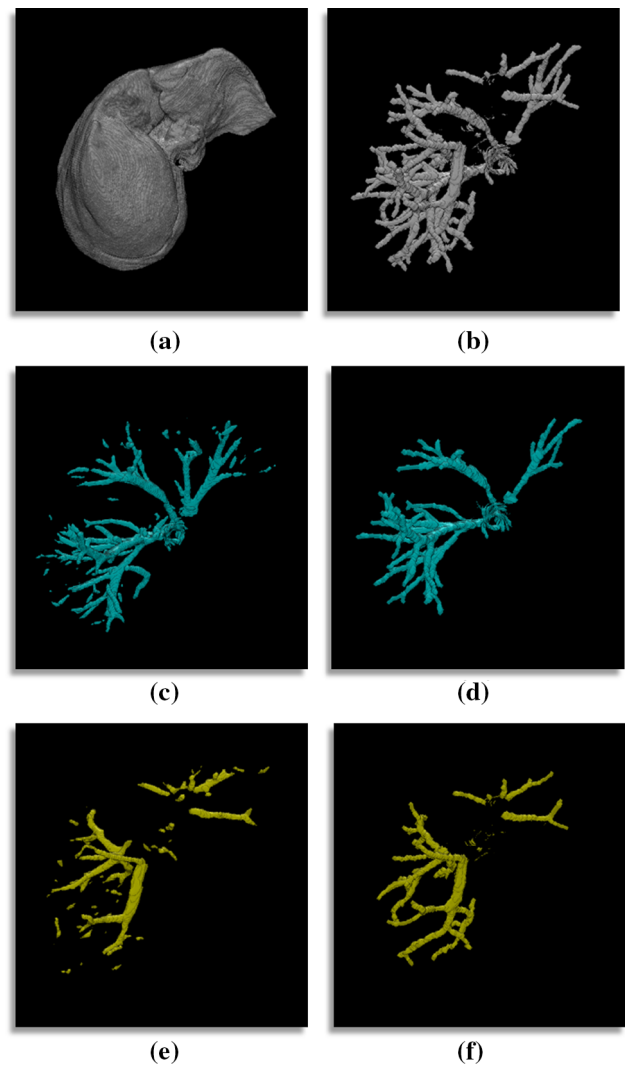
The visualization of segmentation of portal vessel and hepatic vessel. a CT liver volume from IRCAD dataset; b manual label of portal and hepatic vessel; c segmentation prediction of hepatic vessel; d manual label of hepatic vessel; e segmentation prediction of portal vessel; f manual label of portal vessel
